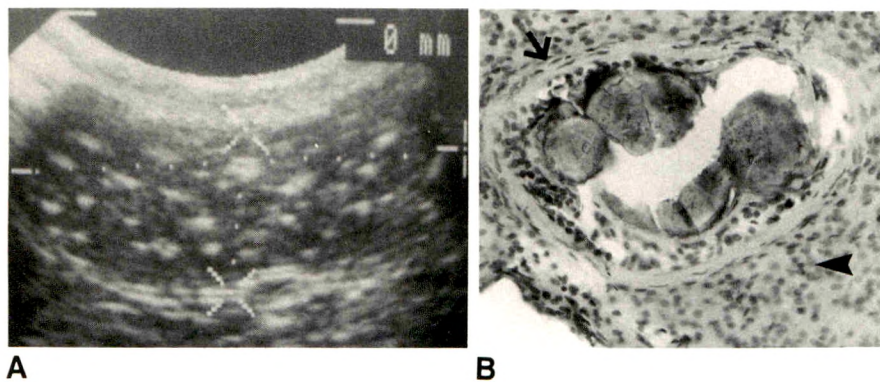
A, Sonogram of right testicle shows multiple hyperechoic foci in otherwise normal-appearing parenchyma.
